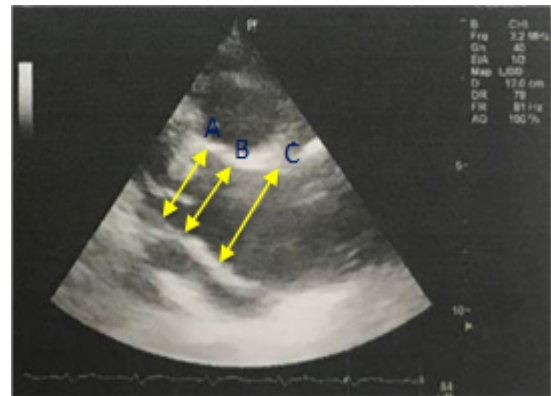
Echocardiograph showing (A) dilatation of sinus of valsava, (B) dilatation of ST junction, (C) dilatation of proximal ascending aorta
